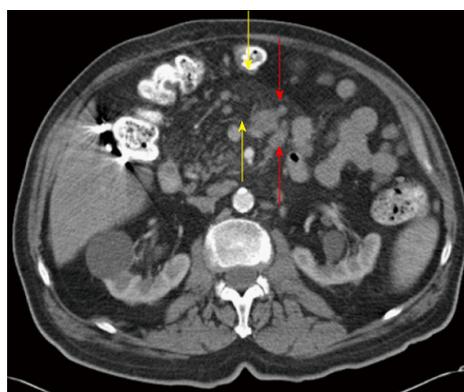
Mesenteric panniculitis in a patient with non-Hodgkin lymphoma. Axial computed tomography image shows synchronous mesenteric adenopathy (red arrows) and mesenteric adenopathy (yellow arrows).
